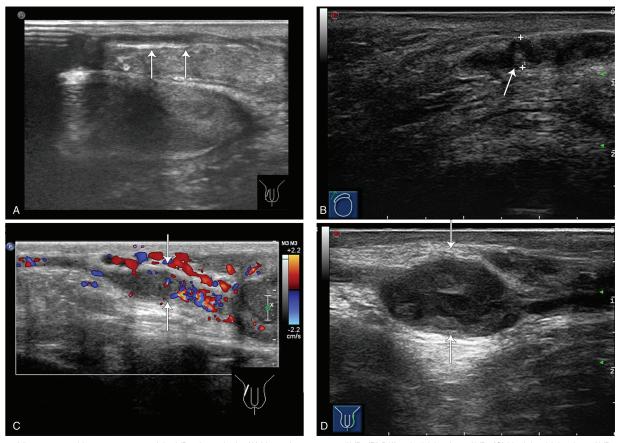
Ultrasonographic appearances of the VD tuberculosis. (A) Normal sonogram of VD, (B) Diffusely thickening of VD, (C) Nodular thickening of VD, and (D) Space-occupying lesions adjacent to the VD. (As indicated by the white arrows, respectively.). VD = vas deferens.
